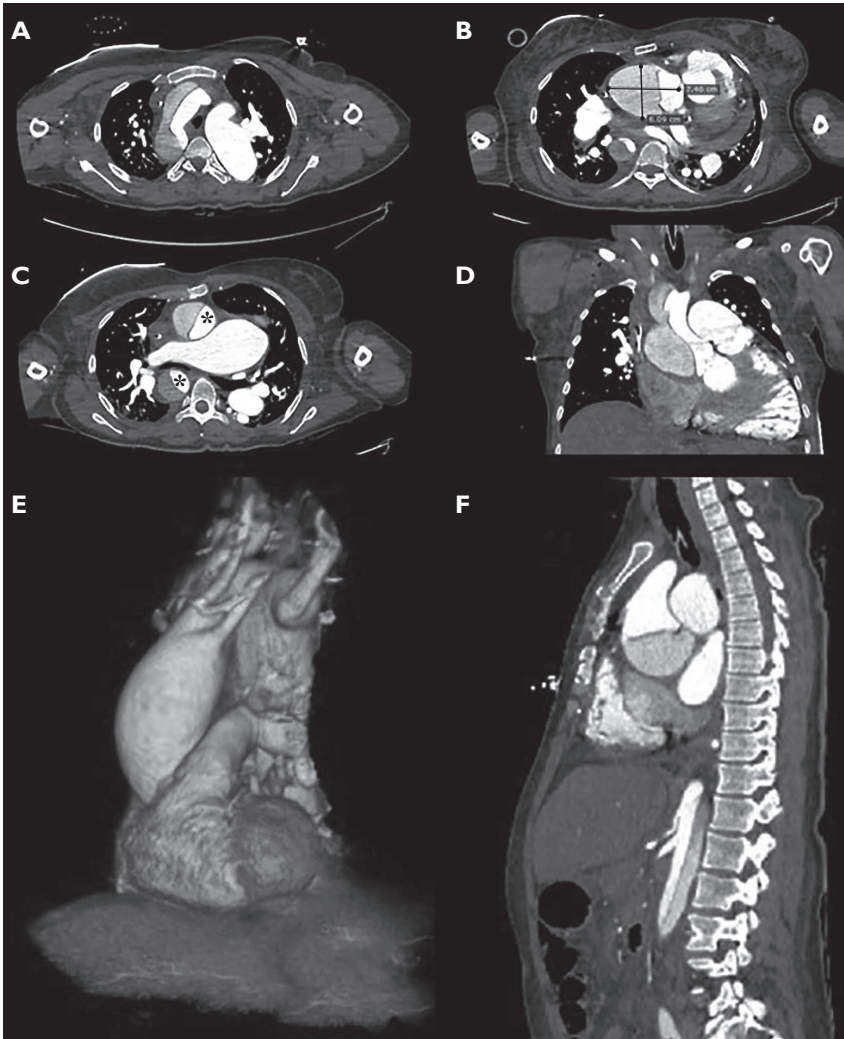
Computed tomography angiography scan revealed a marked aneurysm of the aorta (A) (maximal dimension of 6×7 cm at the ascending aorta – B), with an intimal flap of dissection involving the aortic root, the aortic arch (C, D, E, F), and the right-sided descending aorta and dividing the true lumen (TL) – the star (C), from the false lumen (FL). There is a severe dilatation also of the ascending aorta (arch and descending are involved too). This dilatation is due to the dissection and the formation of a second lumen (false lumen) from the valvular plane and aortic root.
